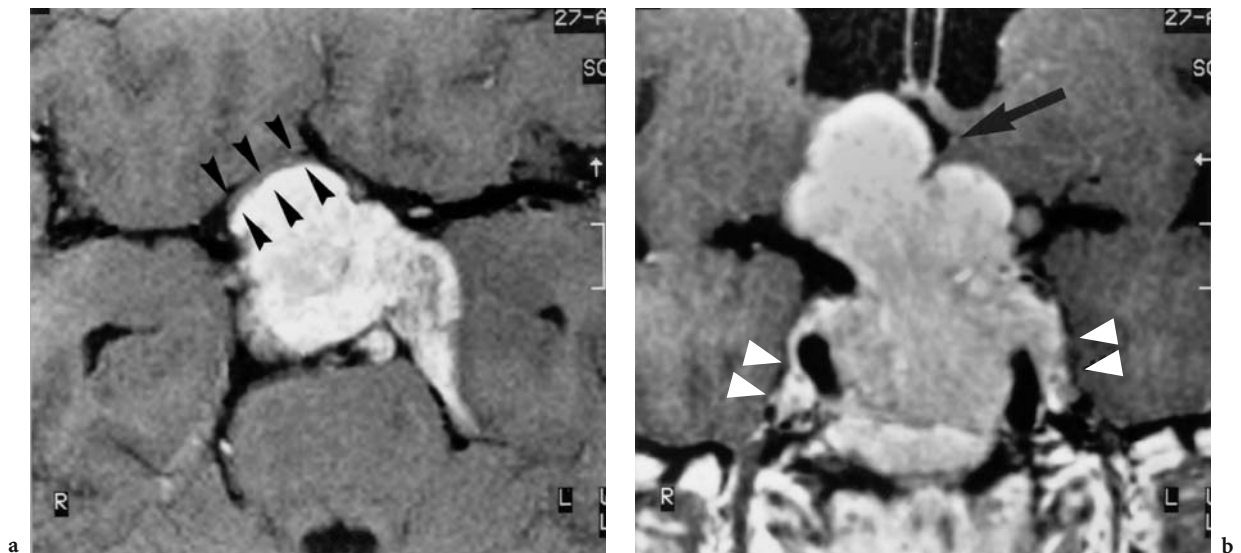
A 39-year-old man with slowly progressing visual deficit. Diagnosis: macroadenoma of the pituitary gland. T1-weighted, contrast-enhanced MRI: a Axial view with anterior dislocation of the optic chiasm (*arrowheads*) and to the right, attenuated and extended by the tumor. b Coronal view demonstrating the entire craniocaudal extension with depression and dislocation of the floor of the third ventricle (*arrow*). The cavernous sinus is infiltrated by the tumor with preference to the left; the small, spheroid hypodensities correspond to cranial nerves V1, V2 (*arrowheads*) and VI medially. (From MÜLLER-FORELL and LIEB 1995)
